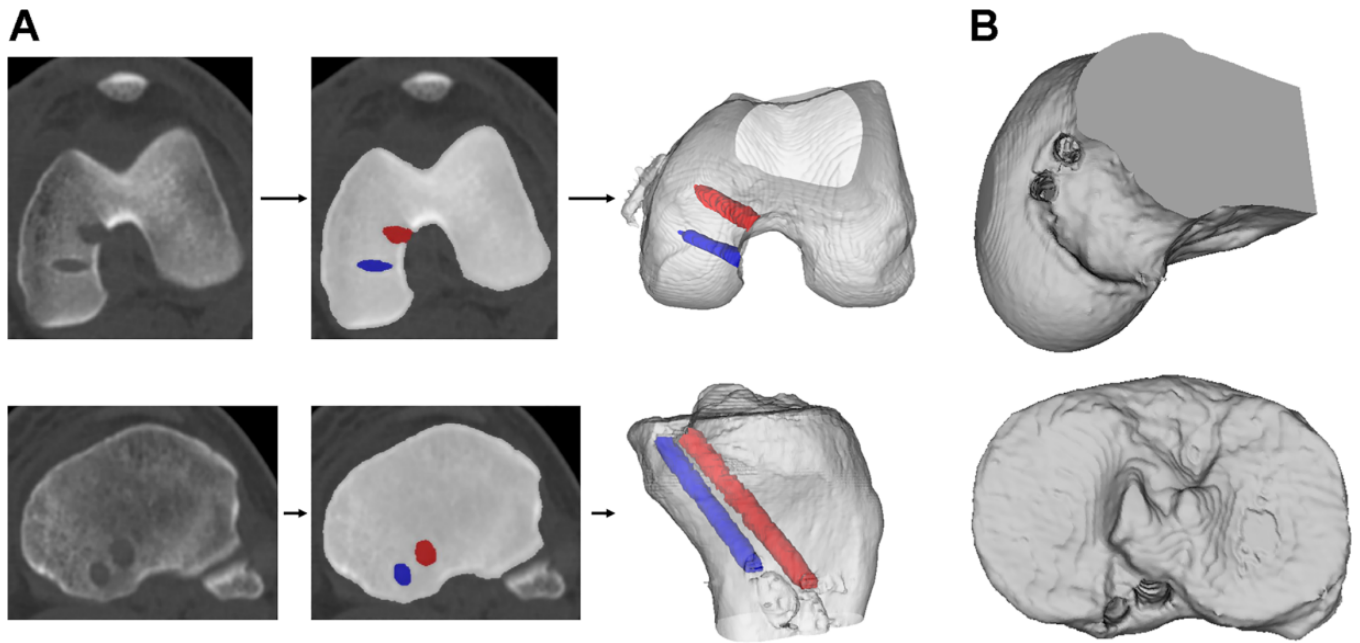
(A) Segmentation and reconstruction to the 3-D models from a CT image. The white, red, and blue 3-D models represent the femur/tibia, anterolateral tunnels, and posteromedial tunnels, respectively. (B) Tunnel apertures on the 3-D CT images. 3-D, 3-dimensional; CT, computed tomography.
